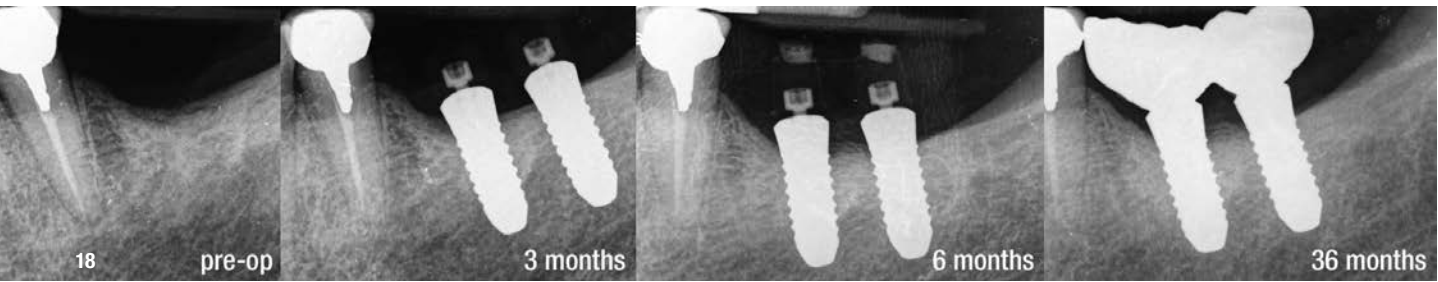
In addition to CBCT, we always produce intraoral images with a centring machine, so that we can evaluate the changes that will be generated over time; more specifically, follow-up will be 36 months.
